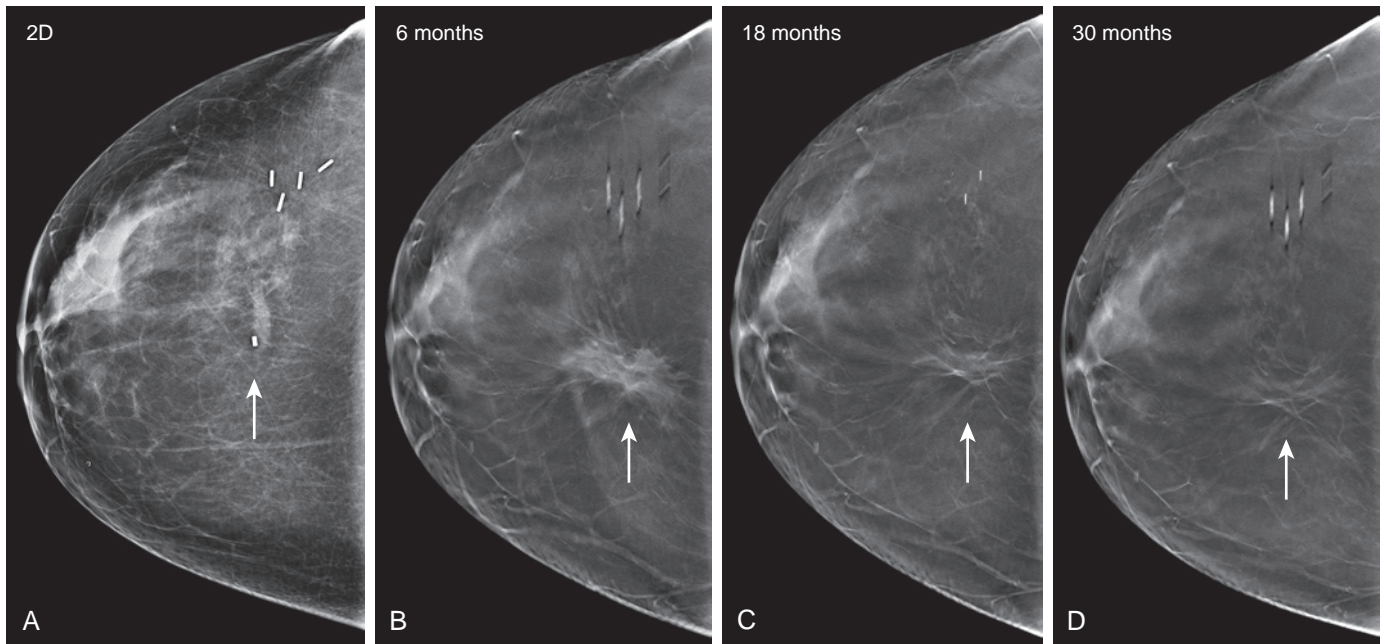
Resolving scar following excision of high-risk lesion. A 51-year-old woman with a strong family history of breast cancer is referred for surgical excision of atypical ductal hyperplasia. A preoperative two-dimensional craniocaudal view (A) demonstrates the magnetic resonance imaging biopsy site marker (*arrow*). Multiple surgical clips in the lateral breast correspond to a previous benign excision. Follow-up postoperative tomosynthesis slices from similar anatomic levels at 6, 18, and 30 months (B-D, respectively) demonstrate a diminishing irregular asymmetry (*arrows*) with a few associated oil cysts, consistent with resolving post-surgical changes. Mild architectural distortion persists.
